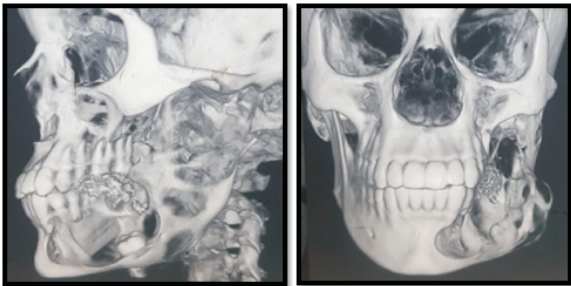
3D CBCT showing bone resorption on affected side.
